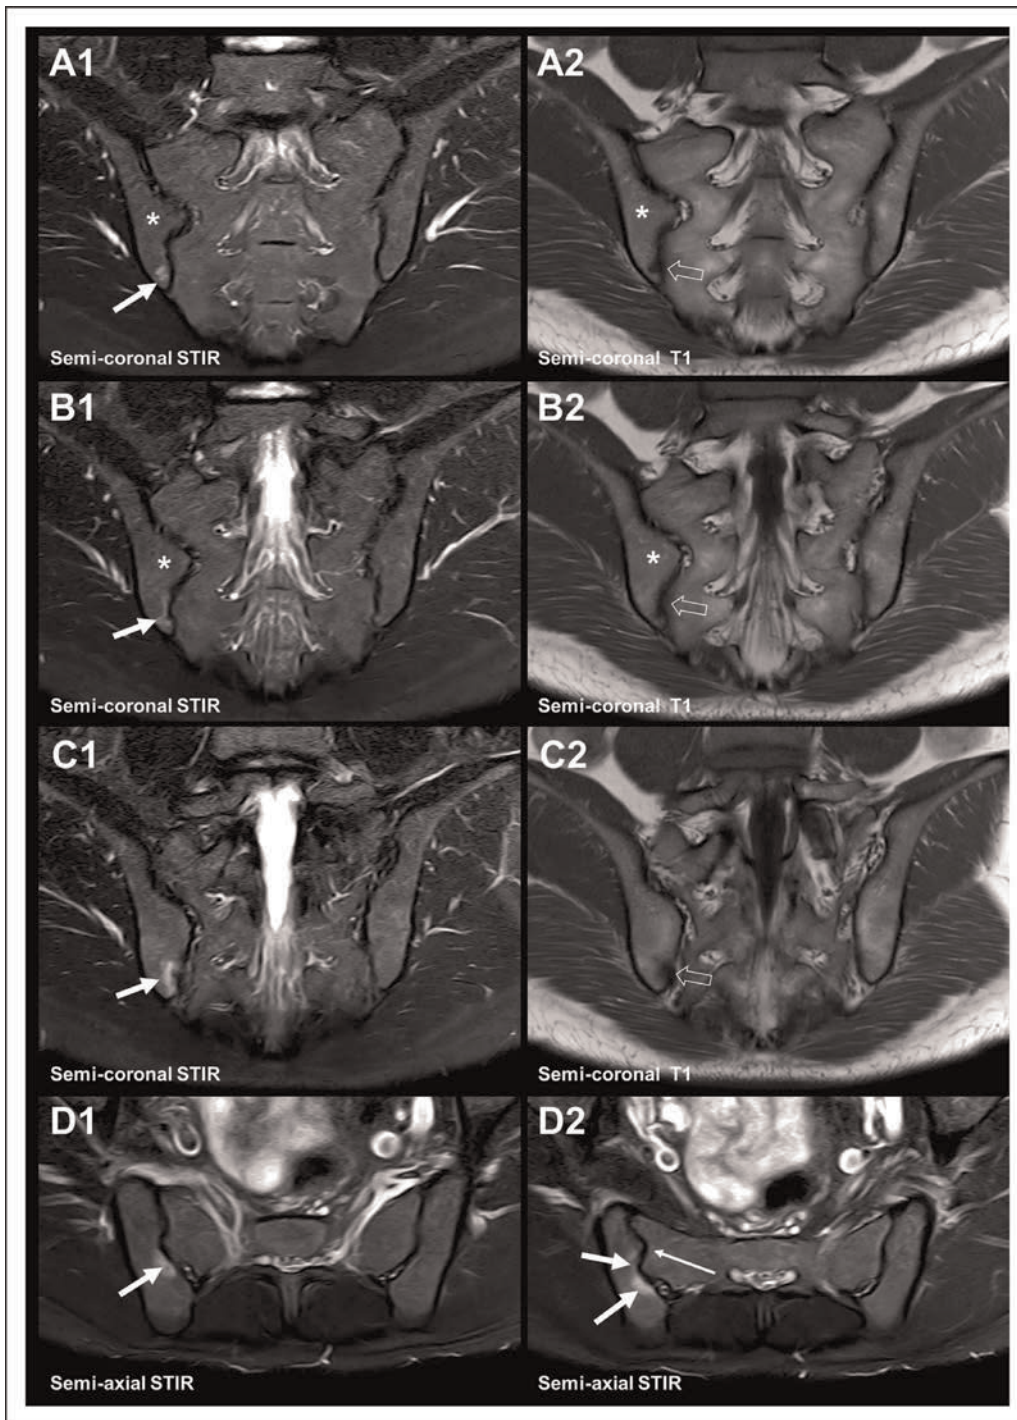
Dysmorphic joint changes and iliosacral complex with concomitant bone marrow edema. MRI in a 28-year-old man with recurrent low back pain for 2 years caused by L5/S1 disk degeneration with posterior disk protrusion; no clinical or biochemical findings suggesting sacroiliitis. Three consecutive semi-coronal STIR (a1, b1, c1) and corresponding T1-weighted images (a2, b2, c2) posteriorly in the SIJ with supplementary semi-axial STIR images at the lower part of the joints (d1 and d2). There is subchondral BME posterior/inferior in the right ilium on all semi-coronal STIR images (arrows on a1, b1, c1). The BME is related to dysmorphic joint changes visible on the semi-axial images as an iliac prominence into the middle of the sacral joint facet (long slim arrow on d2). There is also a right-sided iliosacral complex between the first and second sacral segment (asterisks on a1, a2, b1, b2). The BME causes decreased signal on T1-weighted images (open arrows on a2, b2, c2), but there are no erosions. BME, bone marrow edema; SIJ, sacroiliac joint; STIR, Short Tau Inversion Recovery.
